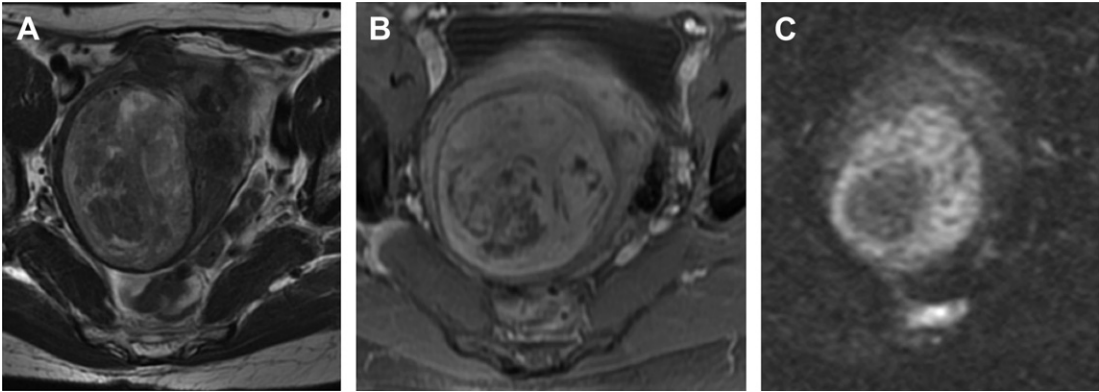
Cellular leiomyomas. Well-circumscribed mass with higher SI on T2-weighted images, marked enhancement on contrast-enhanced images, and high SI on DWIs. (A) T2-weighted image. (B) Postcontrast image. (C) DWI.
